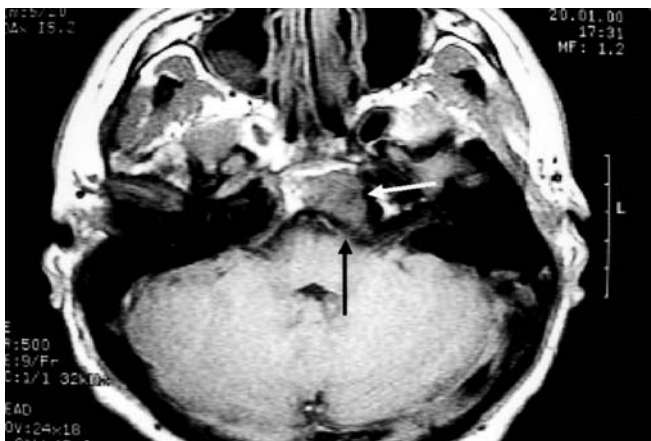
Axial plane. T1-weighted SE image. There is replacement of the left part of the clivus with hypointense lesion (*arrows*). Note the bulging of the left lateral and posterior walls of the clivus due to the slightly expansile nature of the lesion. The right part of the clivus shows normal fatty marrow
